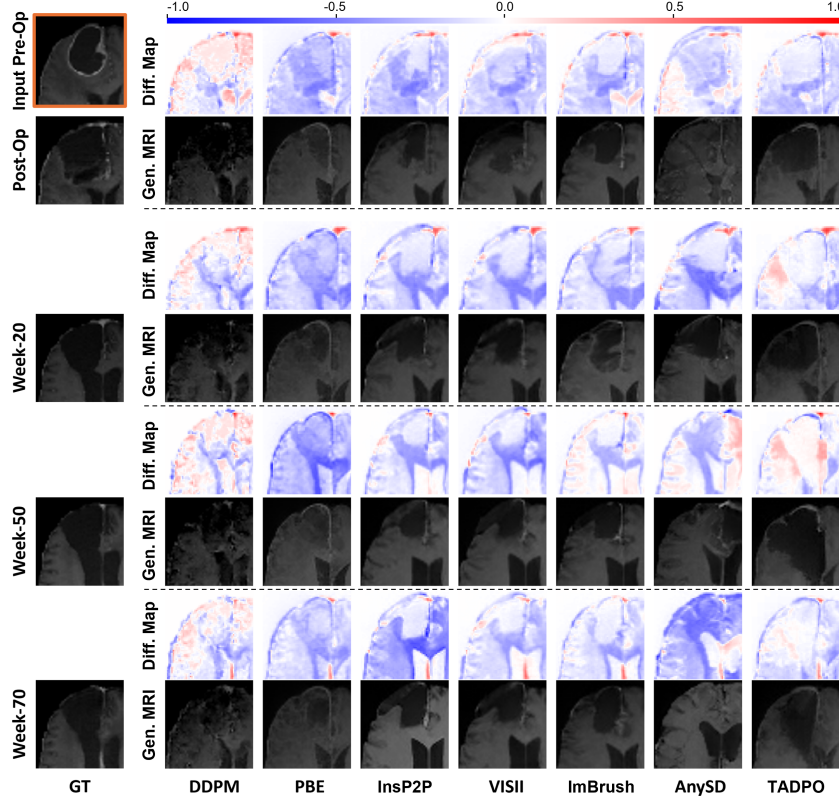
Visualization of generated (Gen.) post-operative (Post-Op) and longitudinal follow-up (Week-20 to Week-70) MRIs from a pre-operative (Pre-Op) MRI. Difference (Diff.) maps between Gen. and ground-truth (GT) MRIs highlight tumor-region errors.
